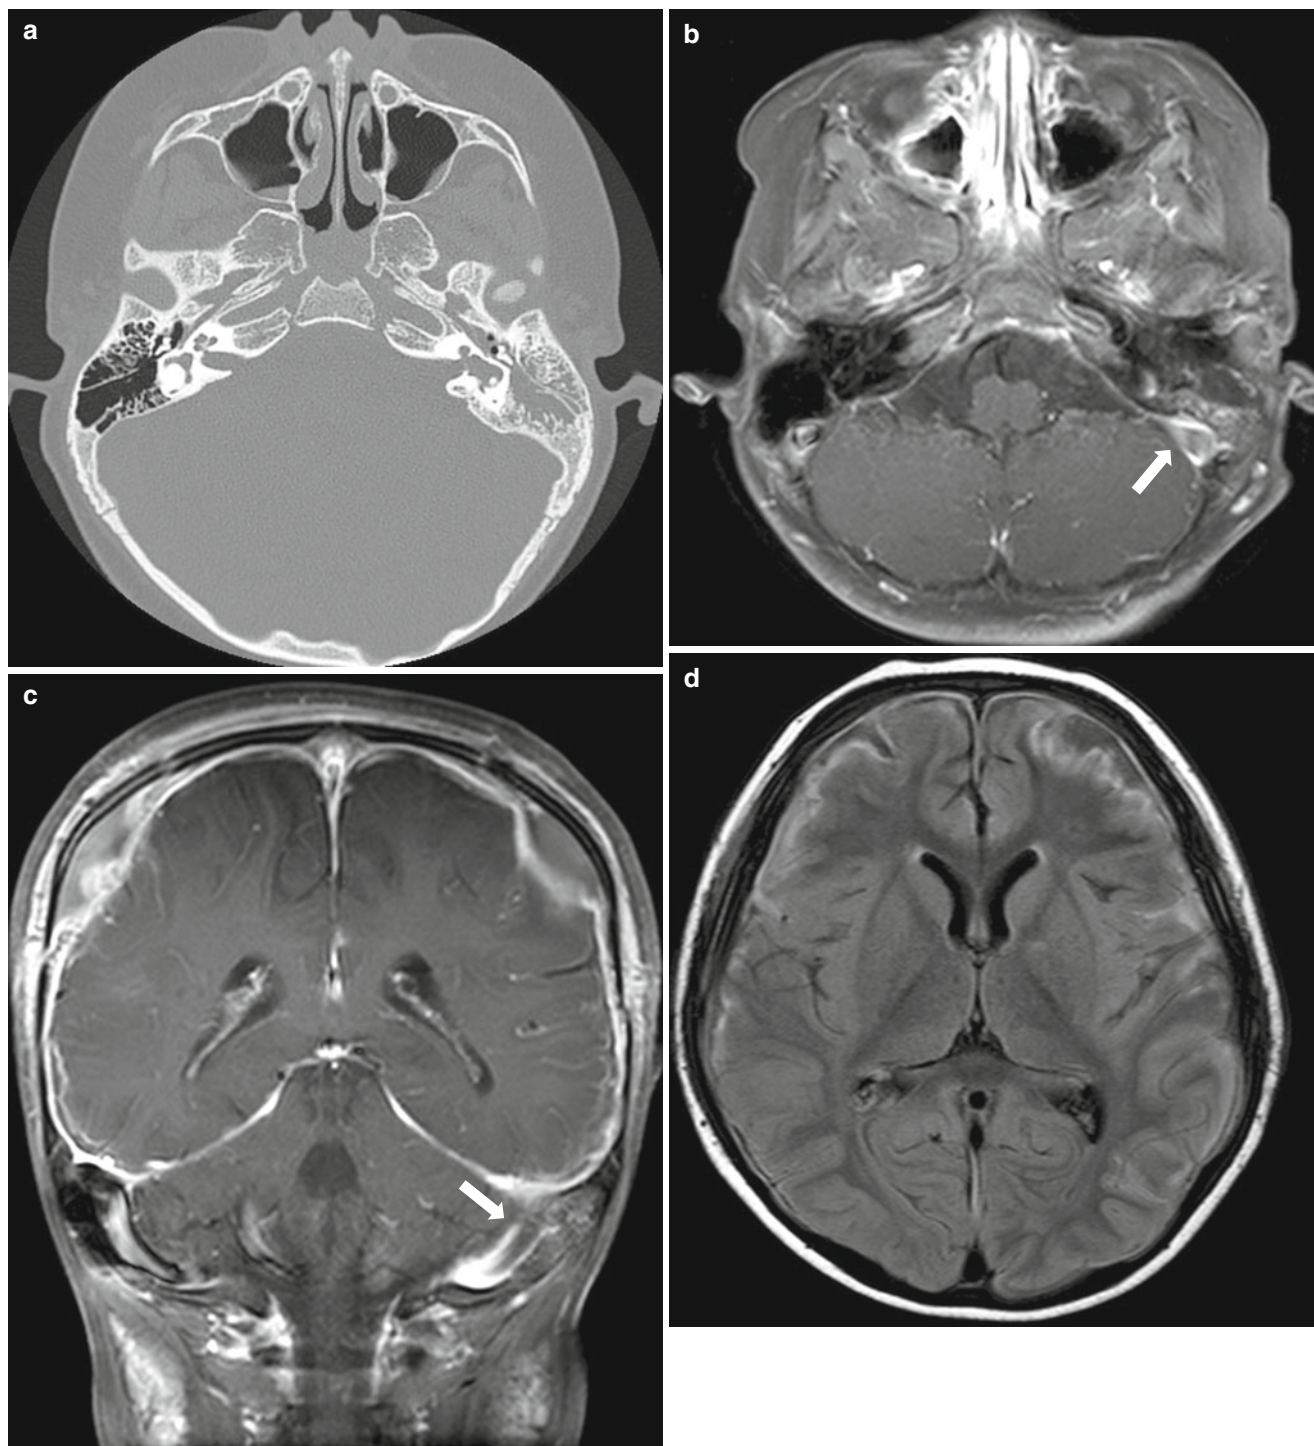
Otomastoiditis with sinus thrombosis and recurrent pneumococcal meningitis. (a) Temporal bone CT shows abnormal soft tissue opacification in the left middle ear cavity and mastoid antrum/air cells. There is underlying congenital cochlear and vesicular dysplasia. Diffuse sclerosis is noted in the mastoid area. (b–d) MR postcontrast fat-suppressed T1-weighted axial (b) and coronal (c) images show
